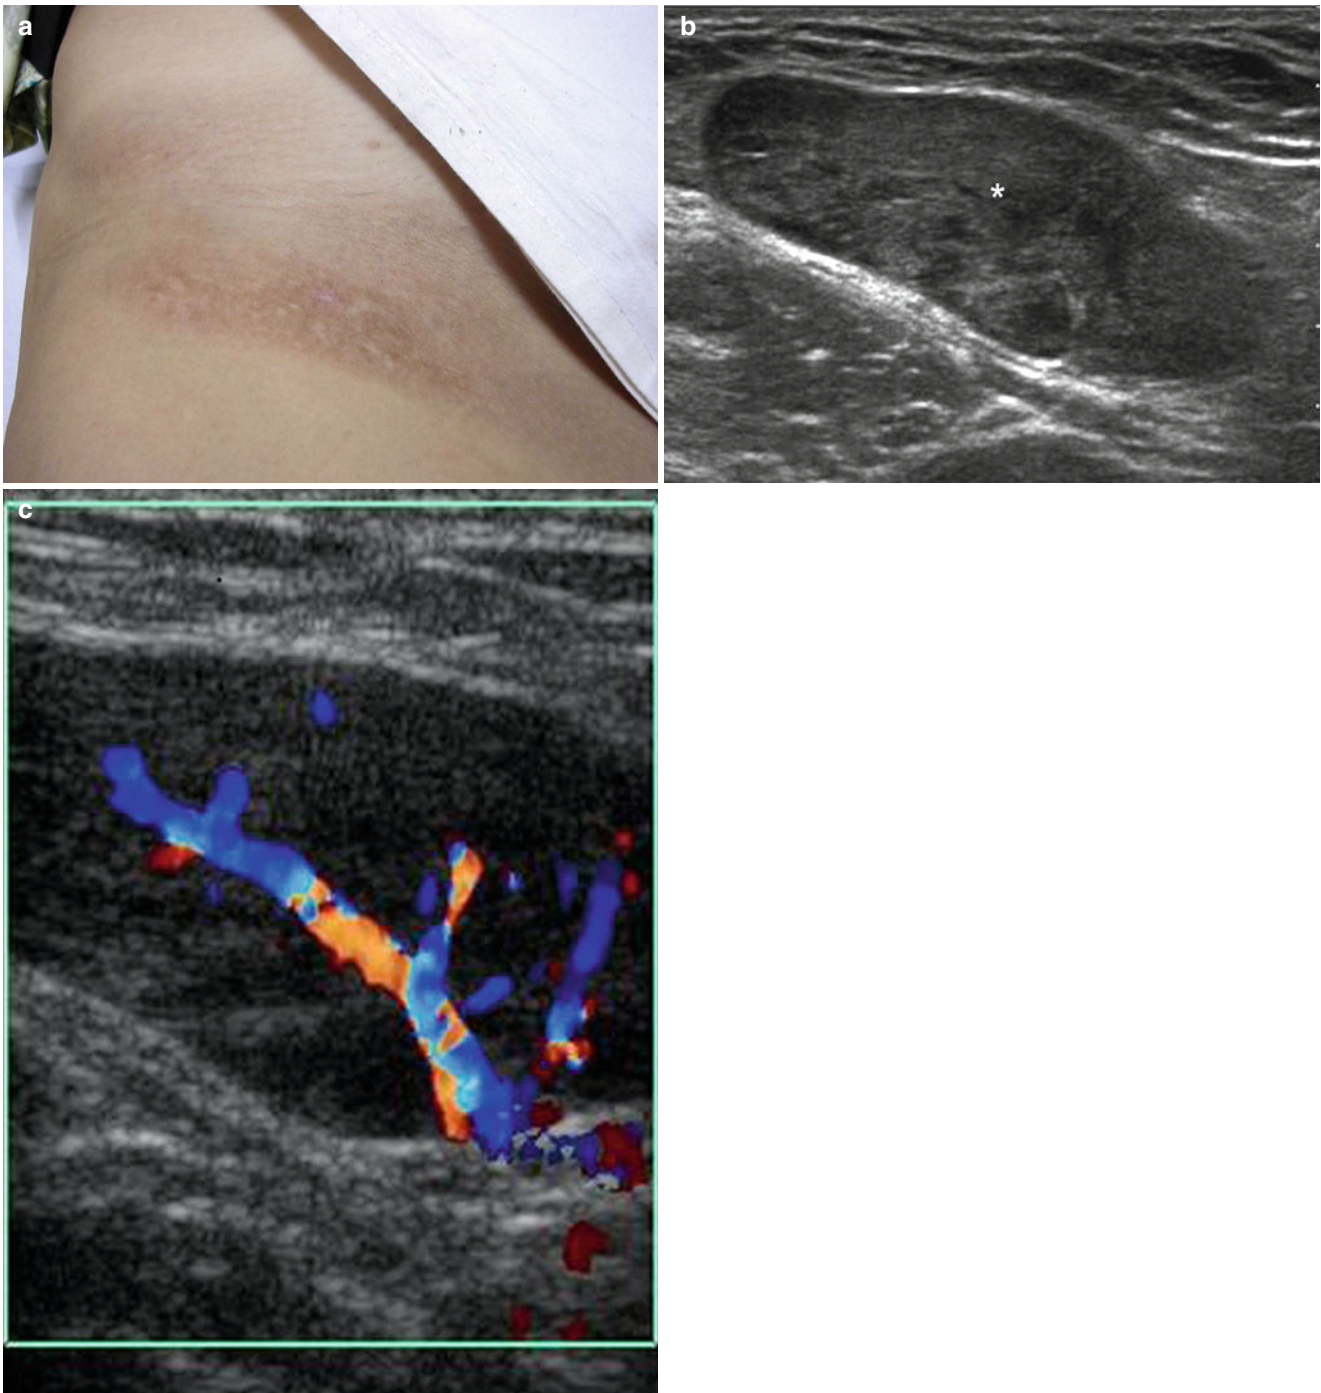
(a–c) Lymphoid hyperplasia lymph node. (a) Clinical image shows pigmentation in the right groin. A mass was also palpable in the same region. (b) Grey scale ultrasound image (transverse view) demonstrates
